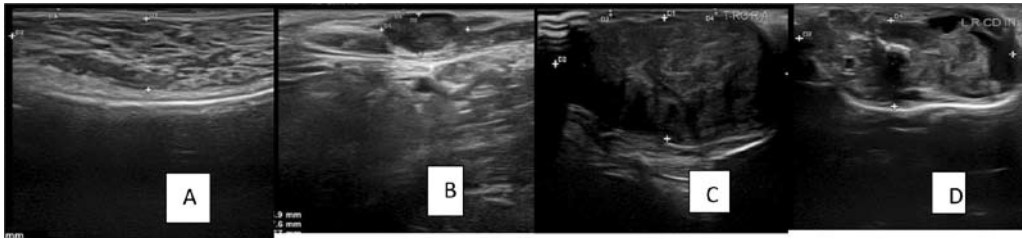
Sonographic images of mammary gland depicting echotexture. (A) Normal healthy mammary gland. (B) Homogenous echotexture of a benign mammary neoplasm. (C) Heterogenous echotexture of a benign mammary neoplasm. (D) Heterogenous echotexture of a malignant mammary neoplasm
